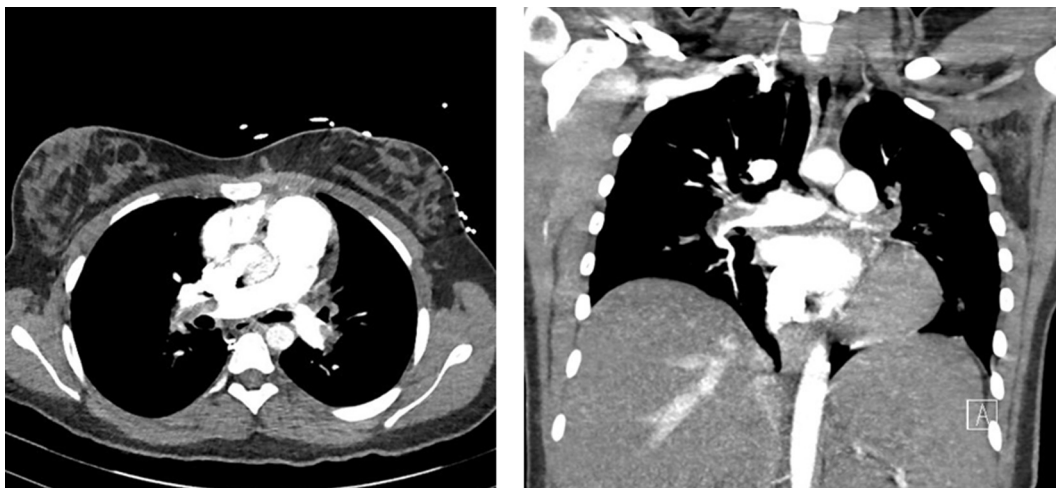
CT pulmonary angiography (CTPA) depicting central pulmonary emboli
